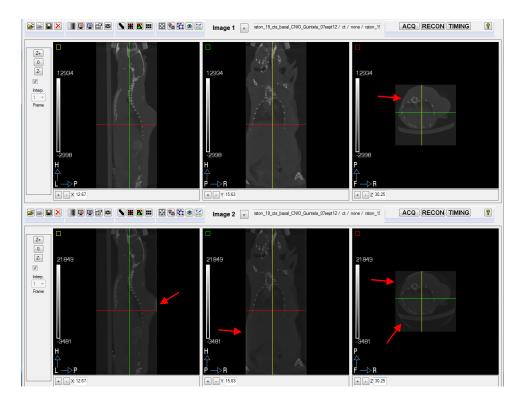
Upper row: sagittal, coronal and axial views respectively of a truncated CT image with truncation correction. Lower row: truncated CT image without truncation correction.
